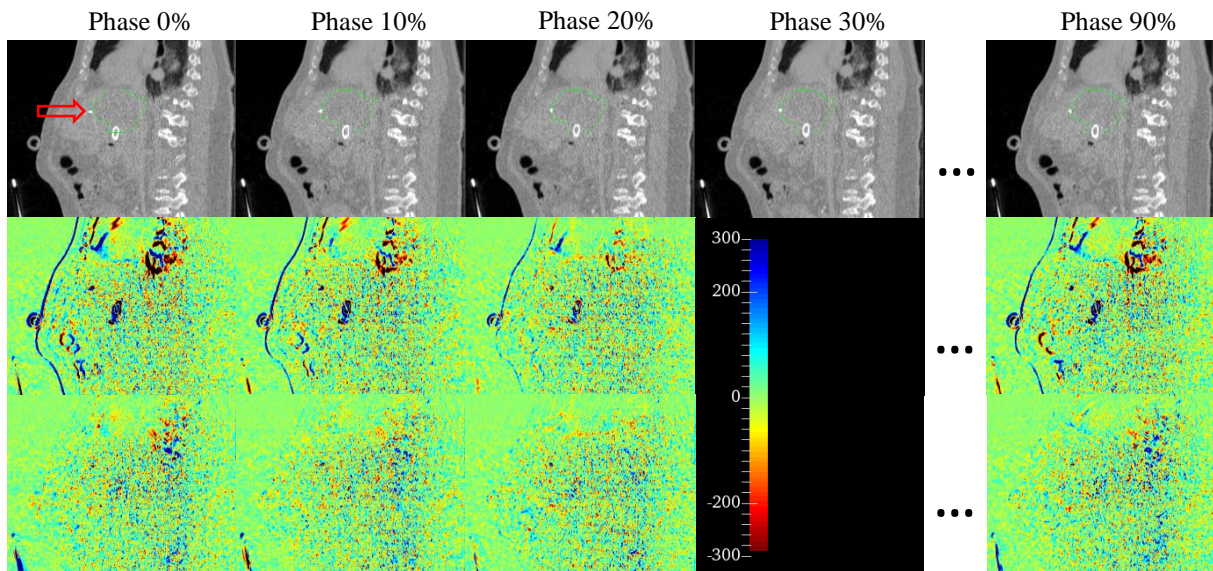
Upper row: sagittal slices of the 4DCT scan of patient LV2; Middle row: Image subtraction between original CT frames and the reference phase (phase 30%) with a colour scale range between -300 and 300 HU; and Bottom row; Image subtraction between warped CT frames and the reference phase (phase 30%) with the same colour scale range. After registration, clearly shown is a reduction of the image difference, where there are no edges visible in images. The red arrow shows the implanted gold marker close to the CTV (green).
